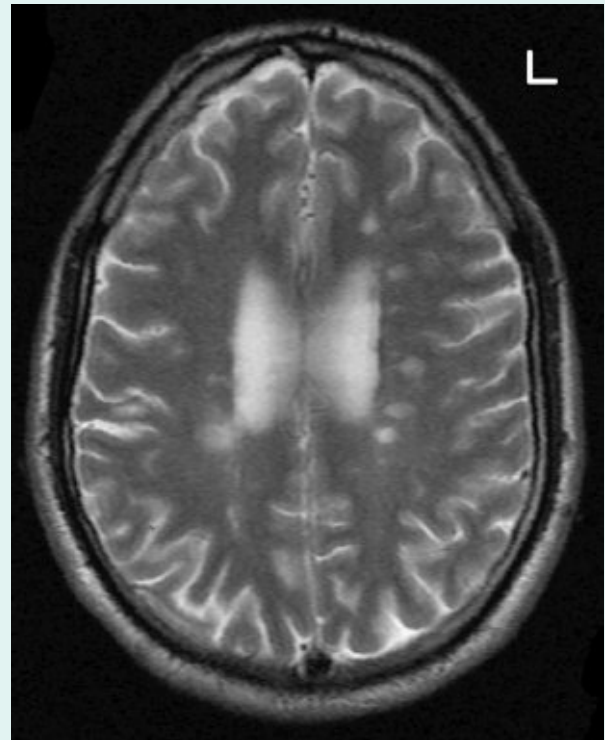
An axial T₂-weighted magnetic resonance image of a 28-year-old man with multifocal demyelination secondary to multiple sclerosis showing multiple high signal intensity lesions in the white matter. On the left side of the brain, at least five of these plaques are periventricular. (Kindly provided by Dr. Joe Walsh, Department of Radiology, University College Hospital, Galway, Ireland.)
